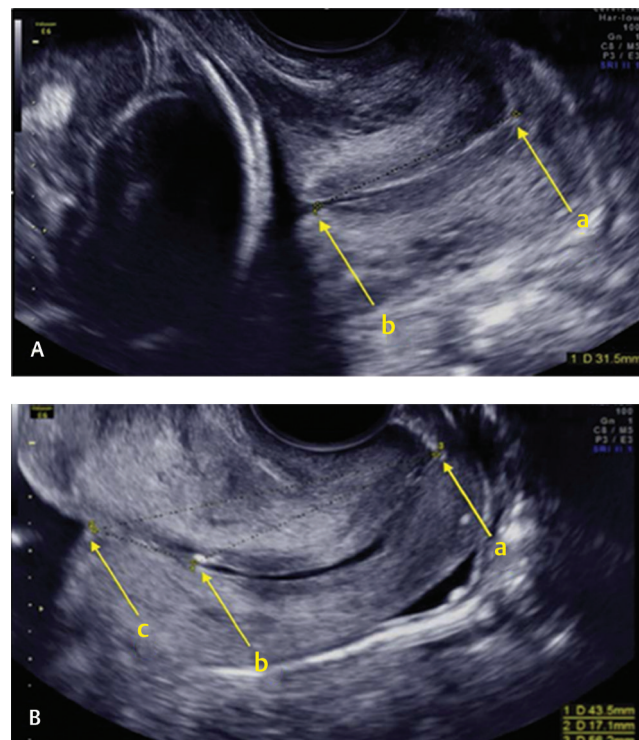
Measurement of cervical length when isthmus is absent (A) or present (B). Isthmus is the lowest part of the uterine corpus that develops into the lower uterine segment as pregnancy progresses. The letter “a” denotes the external os. “b” denotes the internal os. “c” (which we call the “virtual inner os”) is the innermost end of the juxtaposed anterior and posterior isthmus. Measurements were taken as a straight line from a to b (endocervical length), from b to c (isthmus length) and from a to c (second-trimester transvaginal ultrasound measurement of cervical length for prediction of preterm birth: a blinded prospective multicenter diagnostic accuracy study). Prediction of preterm birth is mandatory if there is history of previous preterm birth, previous late miscarriage, and excisional surgery on the cervix has been done.
